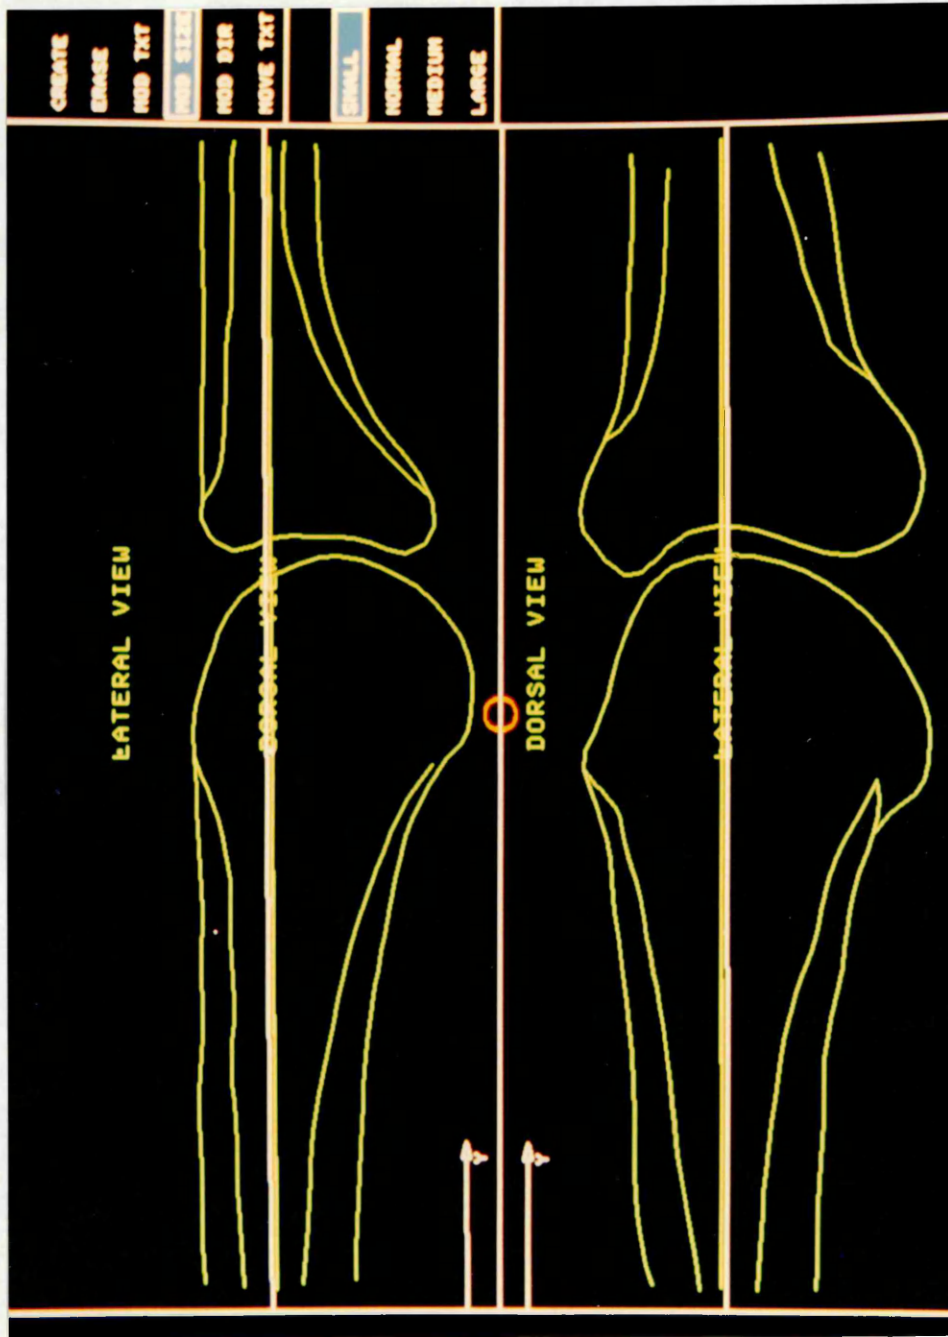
X-ray contour of the bone used for aligning
